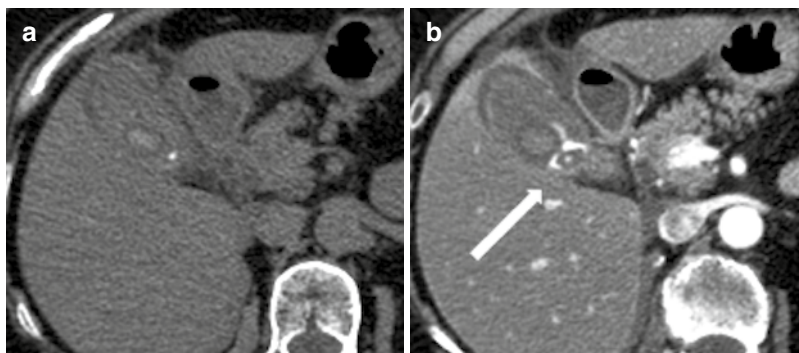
Hemorrhagic cholecystitis in a 69-year-old woman with right upper quadrant pain. (a): Axial unenhanced CT image shows abnormally high-attenuation material within an abnormally distended gallbladder lumen. Gallbladder wall edema is also present. (b): Axial
